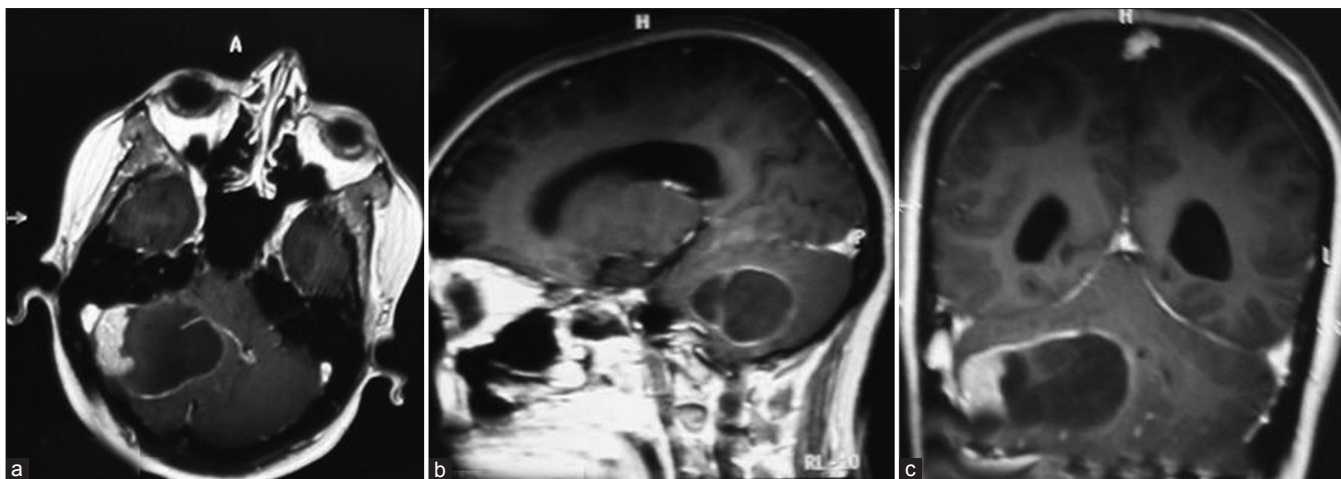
Contrast enhanced MRI images of axial, sagittal and coronal sections of the case showing solid-cystic tumor. Solid portion and lining of the tumor is seen enhancing with the contrast there was no perilesional edema
